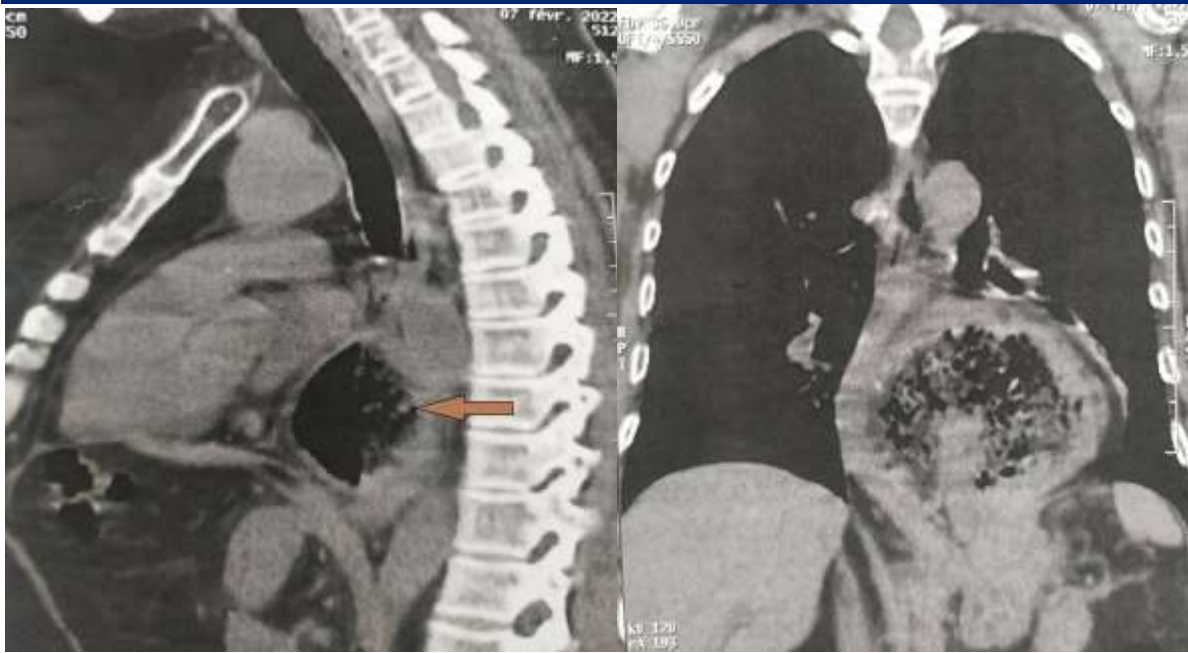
CT scan image of a large hiatal hernia by intrathoracic rolling
